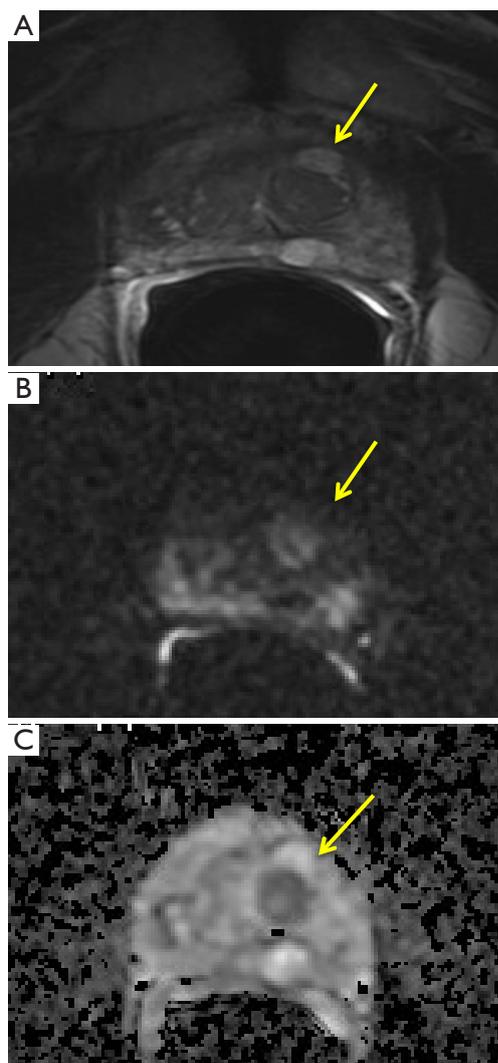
T2 (A), DWI (B) and ADC map (C) in healthy patient. Yellow arrows show central glandular adenoma. DWI, diffusion weighted imaging; ADC, apparent diffusion coefficient.
